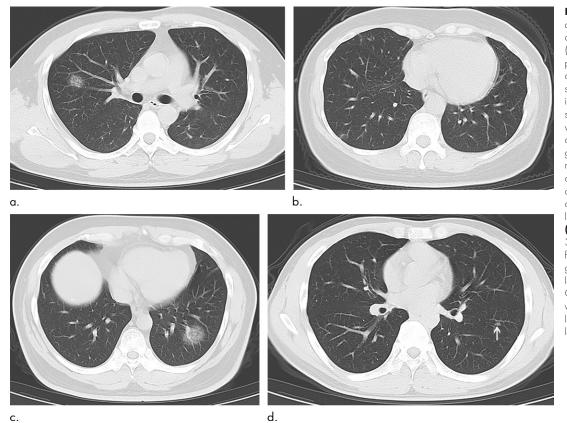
Examples of atypical chest CT findings of coronavirus disease 2019 (COVID-19) infection in patients with epidemiologic and clinical presentation suspicious for COVID-19 infection. (a) Axial chest CT scan in 36-year-old man with cough for 3 days shows a small focal and central ground-glass opacity in right upper lobe. (b) Axial chest CT scan in 40-yearold woman with fever for 2 days shows small peripheral linear opacities bilaterally. (c) Axial chest CT scan in 38-year-old man with fever for 4 days shows a groundglass opacity in central left lower lobe. (d) Axial chest CT scan in 31-year-old man with fever for 1 day shows a linear opacity in left lower lateral mid lung
